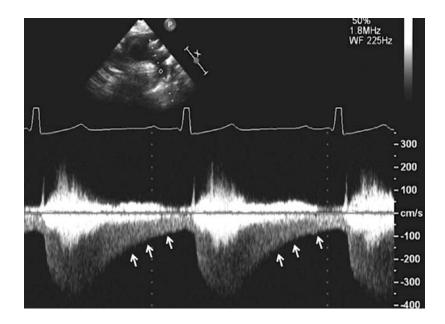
Spectral CW Doppler through coarctation of aorta in descending aorta shows the increased peak systolic flow velocity with anterograde diastolic flow (white arrow) so called diastolic tail
